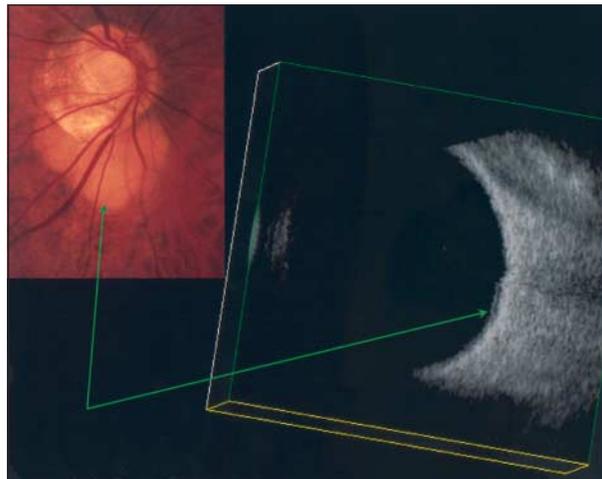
Case 5. A 3-dimensional B-scan ultrasound examination reveals the presence of a localized detachment corresponding to the peripapillary detachment in pathologic myopia in the same patient (arrows).
